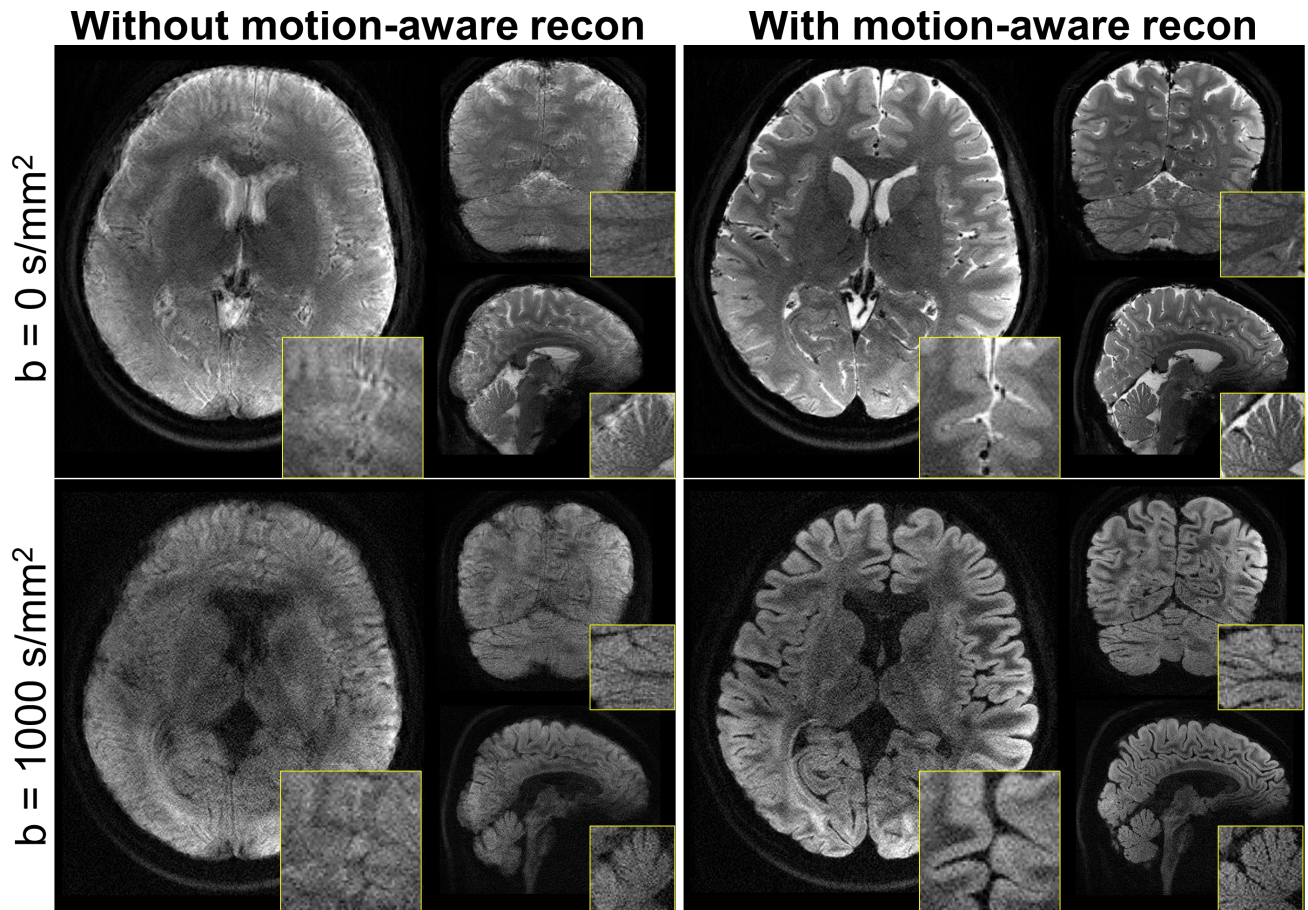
Results of in-vivo motion experiment comparing non-DW and DWI Romer-EPTI images without and with motion-aware reconstruction. Mesoscale $500\mu\text{m}$ -iso dMRI data were acquired at 3T while the subject was asked to deliberately move the head during the scan (with translation and rotation movements up to ~ 6 mm/degrees). Without proper motion correction, severe image blurring and artifacts appear in both the $b=0$ s/mm^2 and DWI images after super-resolution reconstruction. In contrast, the proposed motion-aware reconstruction cleans up these blurring artifacts and provides sharp high-resolution images with high image quality, as can be seen in the zoomed-in images, demonstrating the high motion robustness of Romer-EPTI.
